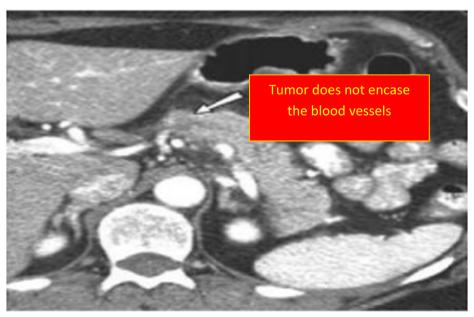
CT Scan image predicting the spread of tumor with respect to blood vessels
